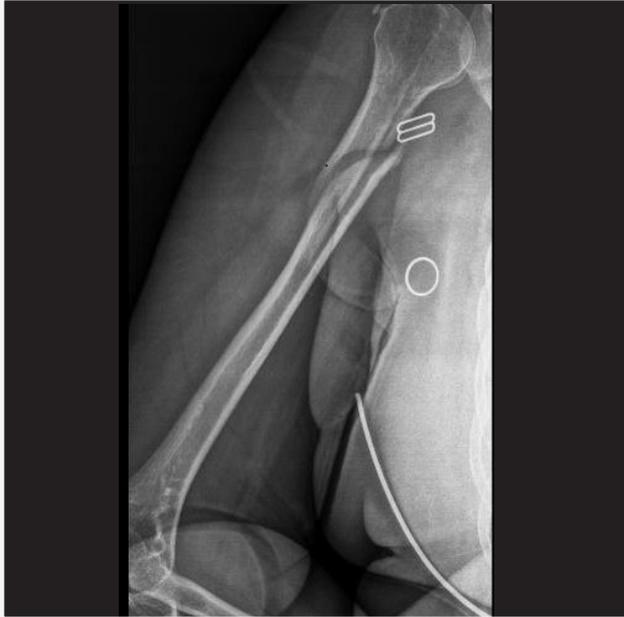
The radiograph of a 64-year-old female patient at the time of first admission
